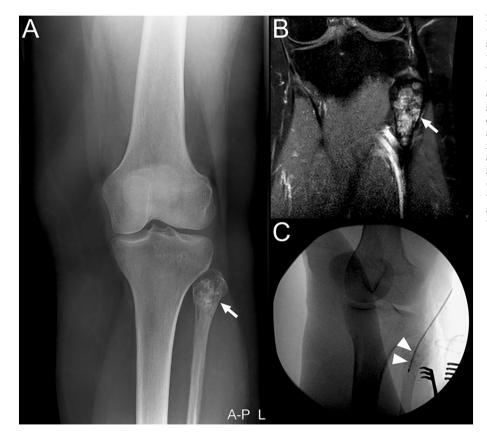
Incidentaloma with low-risk malignant potential in a 51-year-old woman who was referred to a specialized sarcoma center. Knee radiography, which was performed because of stiffness, showed a lesion with cartilaginous calcifications in the proximal fibula (A, arrow). Subsequent (coronal gadolinium chelate-enhanced fat-suppressed T1-weighted) MRI showed a relatively well-circumscribed, lobulated, contrast-enhancing lesion in the proximal fibula (B, arrow), without any signs of aggressive growth (i.e. no endosteal scalloping, cortical destruction, or extraosseous expansion). Findings are compatible with an atypical cartilaginous tumor. The lesion was biopsied (which confirmed a cartilaginous tumor) and underwent subsequent radiofrequency ablation (C, with arrowheads showing the radiofrequency electrode tip).
